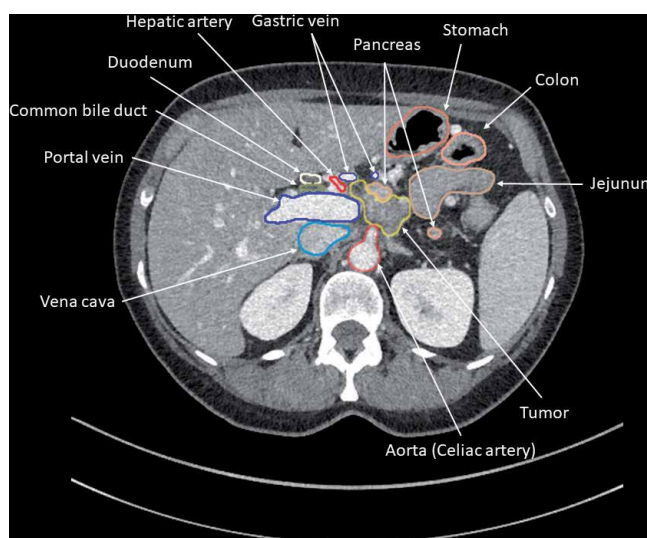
Axial computed tomography image of a patient with LAPC where the tumor encapsulates the celiac artery.
